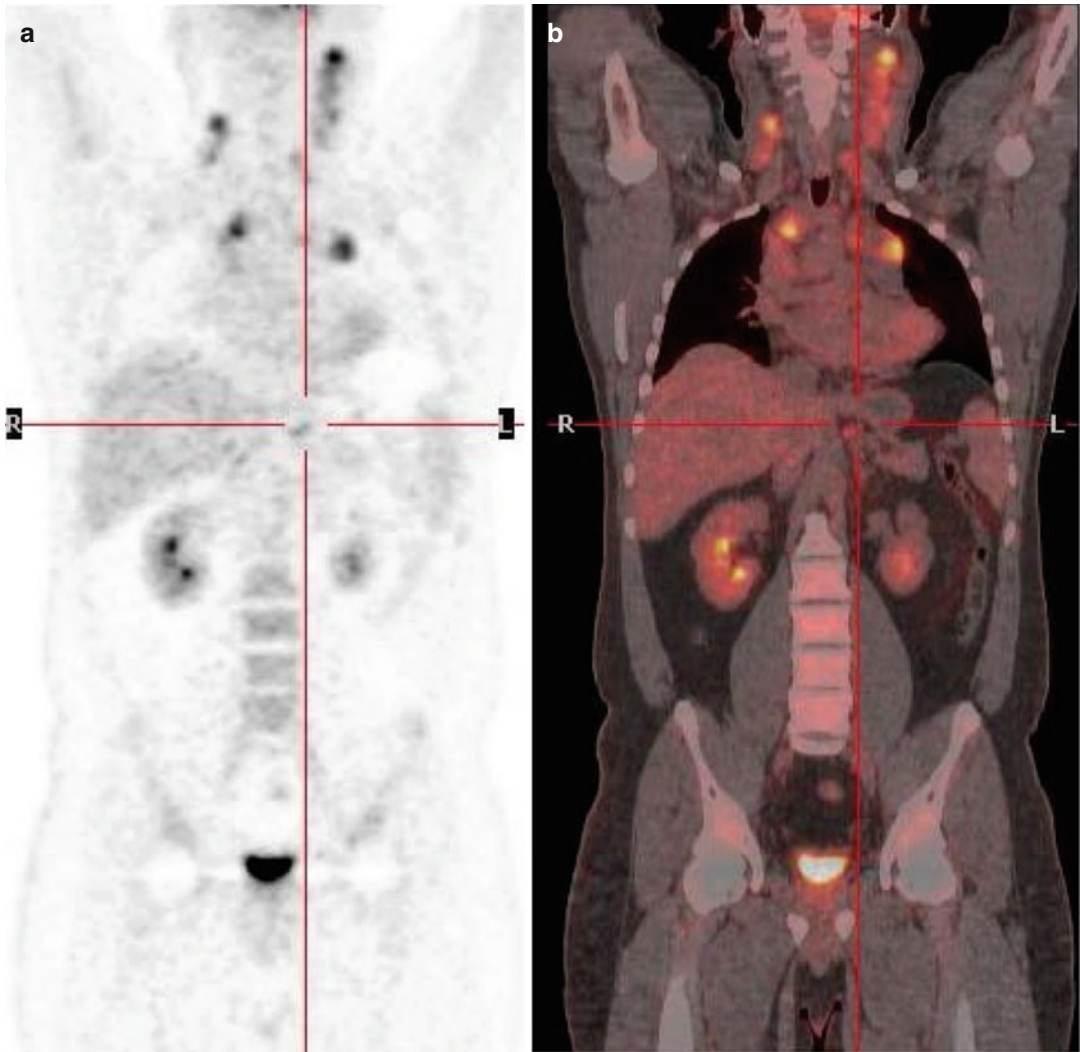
(a, b) PET/CT primary staging demonstrated a borderline-sized hypermetabolic abdominal finding
